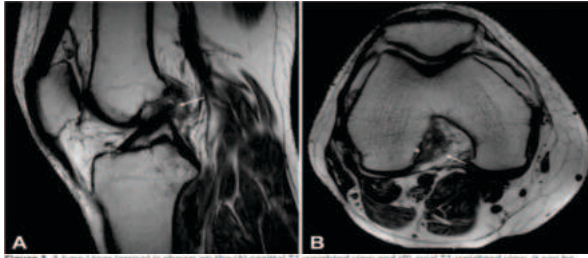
A type I tear (arrow) is shown on the (A) sagittal T1-weighted view and (B) axial T1-weighted view. It can be noted that the ligament is avulsed with only a few fibers remaining on the femoral wall (posterolateral).
